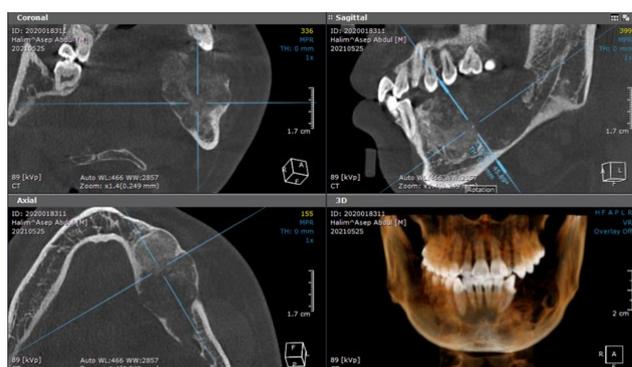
CBCT multiplanar view
